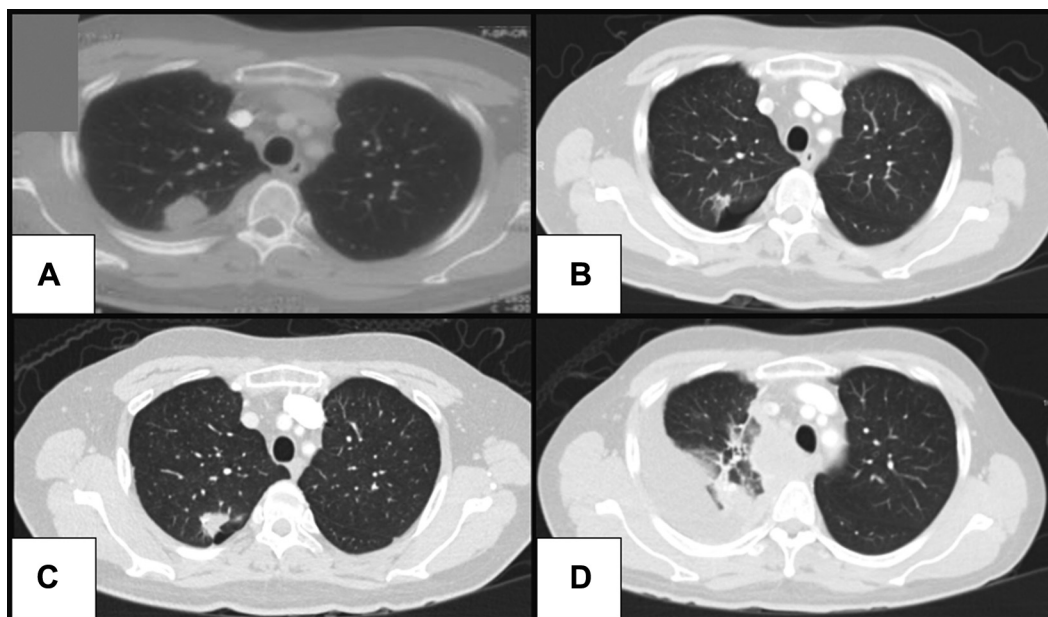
Serial contrasted computed tomography scan of the patient's thorax. (A) November 2015: nodule in the right upper lobe with ipsilateral pleural effusion at diagnosis. (B) February 2016: significant reduction in size of the primary tumor and complete resolution of the right pleural effusion after 3 months of gefitinib therapy. (C) May 2016: increase in size of the primary lung lesion and appearance of new lung nodules. (D) February 2017: marked increase in size of the primary tumor and recurrence of right pleural effusion prompting liquid and repeat tissue biopsies.
